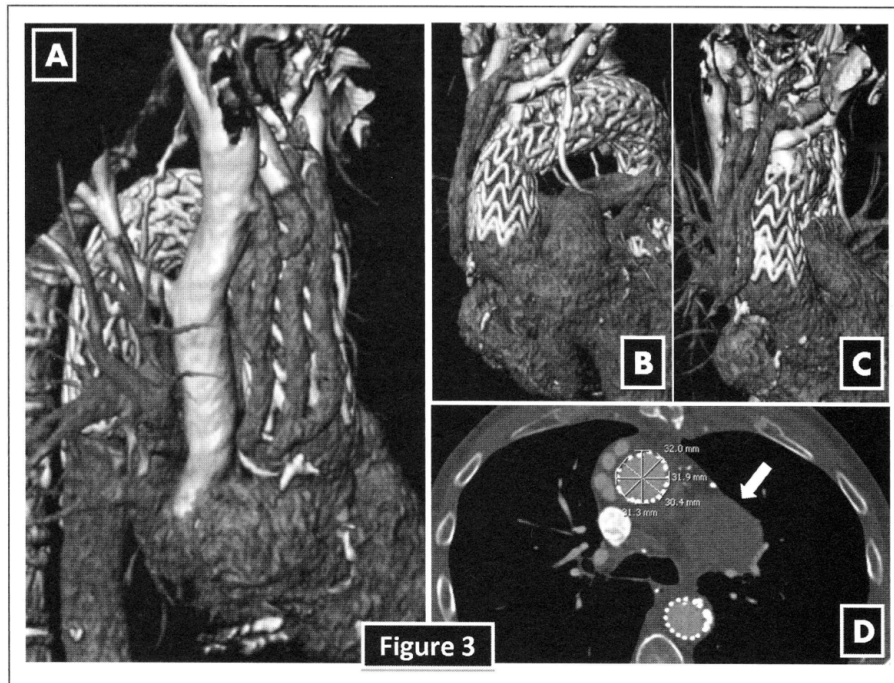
Follow-up computed tomography angiography performed 6 months postoperative. A,B,C, three-dimensional reconstructions showing patent supraaortic trunks and thoracic endovascular aneurysm repair extending from zone 0 to zone 4. D, Maximal aortic diameter of ascending aorta. Arrow: complete thrombosis of the residual ductus Botalli aneurysm.
